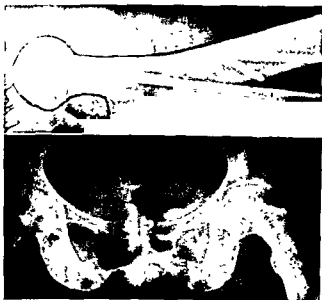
(Top) Lateral roentgenogram with pin fixation. (Bottom) Fixation removed after 64 days showing good results in left hip. Later the right hip was treated for the same type of fracture.
